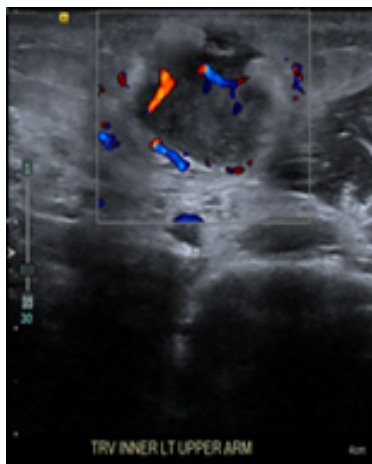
Initial Ultrasound of Left Upper Extremity (1/18/22).
